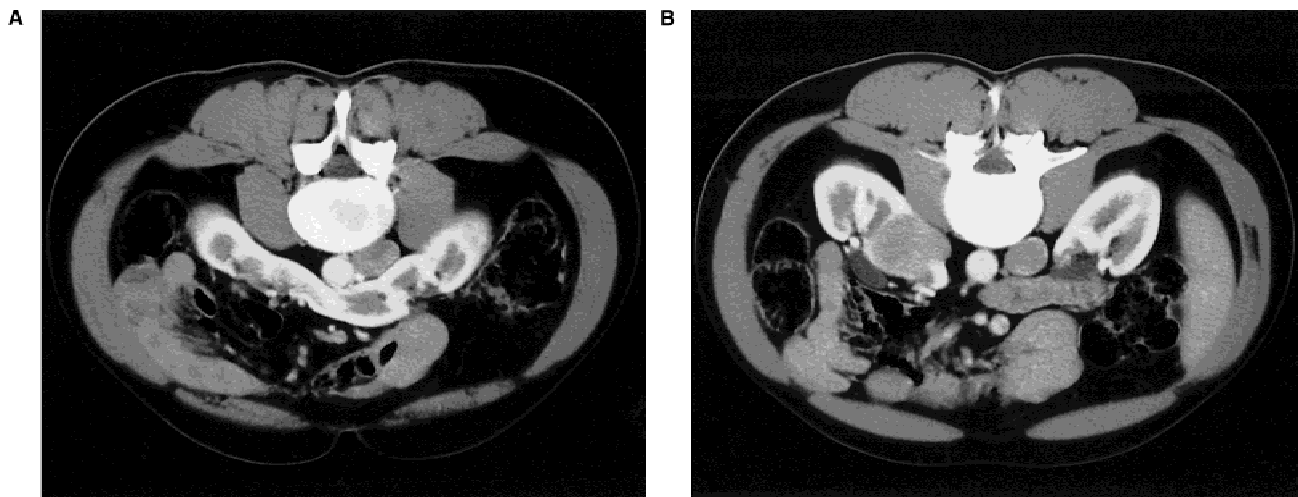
CT scan showing horseshoe kidney (A) with superimposed well-circumscribed, homogeneous and solid mass (B) in the left region, medial to the isthmus.
